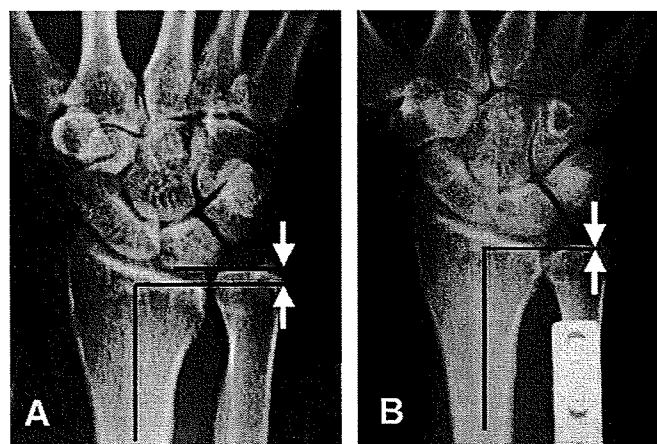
(A) The length of the removed segment equals the amount of positive ulnar variance (arrows) measured on the posteroanterior radiograph. (B) Zero ulnar variance is achieved after ulnar shortening osteotomy and fixation with a six-hole small dynamic compression plate. Joint space narrowing of the DRUJ is found at 16 months postoperatively.
